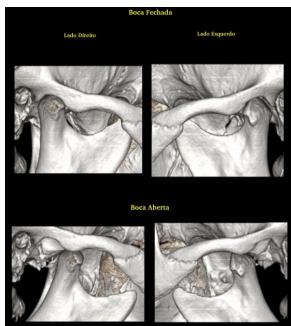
TC Cone Beam Mouth Closed.
